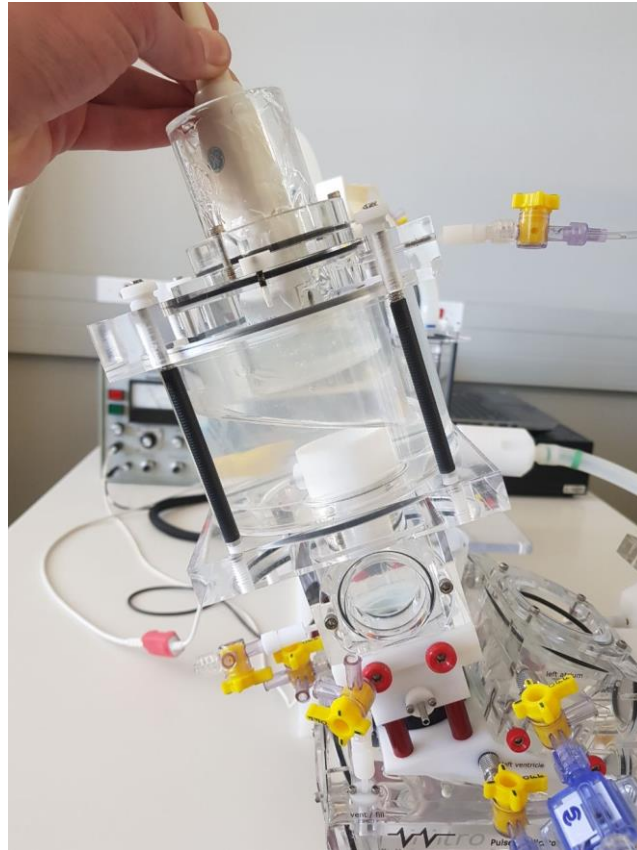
Echocardiographic viewing chambers in a ViVitro pulse duplication system
